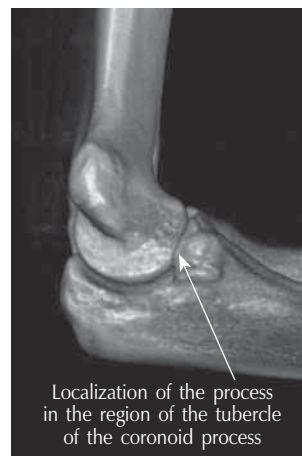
Computed tomography in 3D mode
